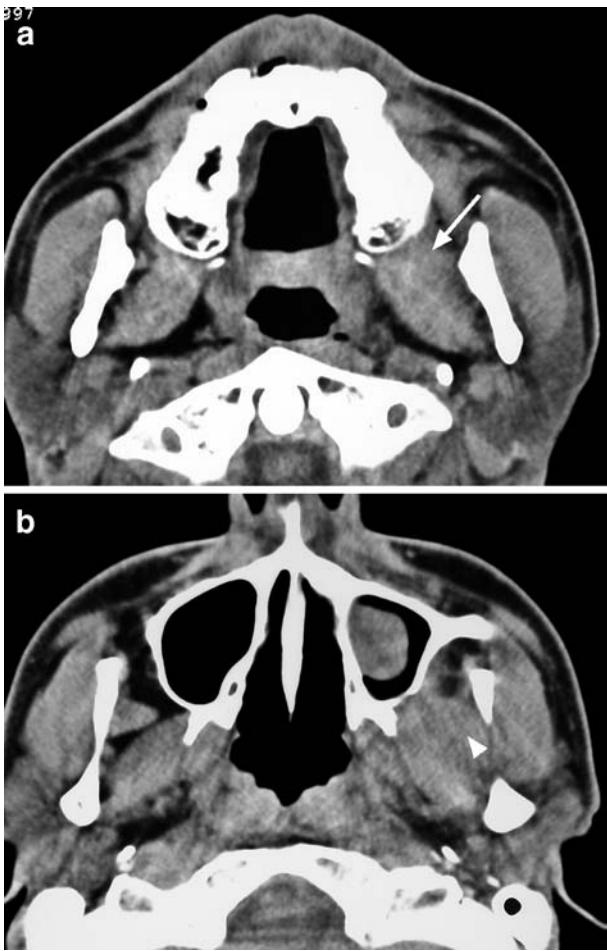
Axial CT image of a patient with a second-molar infection demonstrates enlargements of the medial pterygoid (arrow; a) and temporal muscles (arrow head; b)
